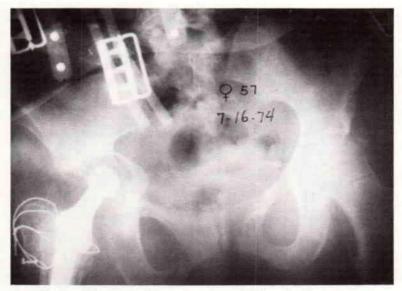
X-rays of the pelvis of the patient shown in Figure 2 with the orthosis on. Notice the inclination and good coverage of the femoral component.
